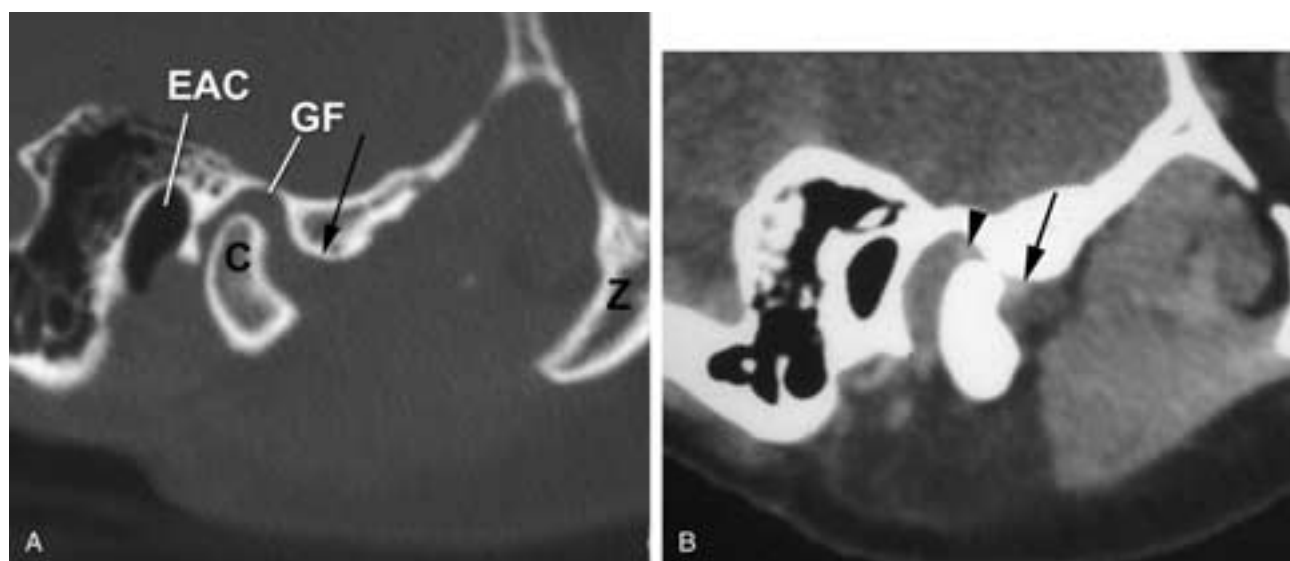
Direct sagittal CT of the TMJ. A, Bone algorithm shows the position of the condyle (*C*) in the glenoid fossa (*GF*) in the closed-mouth position. *EAC*, External auditory canal; *arrow*, articular eminence; *Z*, zygoma. B, Soft-tissue algorithm with the mouth slightly open. The condyle has moved slightly anteriorly and is not completely seated in the glenoid. There is good visualization of the disk. Anterior thick band (*arrow*), posterior thick band (*arrowhead*).
